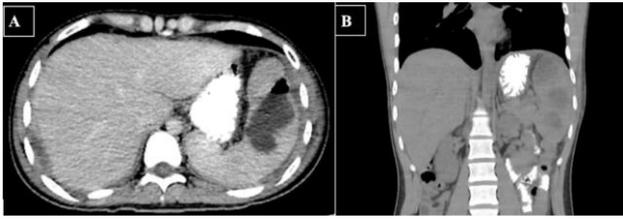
(A and B): CT scan of the abdomen with the presence of a splenic lesion with well-defined borders and the presence of gas inside. CT scan of the abdomen with coronal reconstruction showing the presence of a spleen with increased dimensions of 13.0×5.5 cm with two collections of 6×4.2 cm and 3.3×1.6 cm, with 17 HU.
